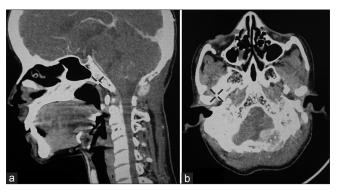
Computed tomography scan done at 2 month, sagittal (a) and axial (b) view demonstrating near total decompression of the craniovertebral junction with minimal residual tumor
